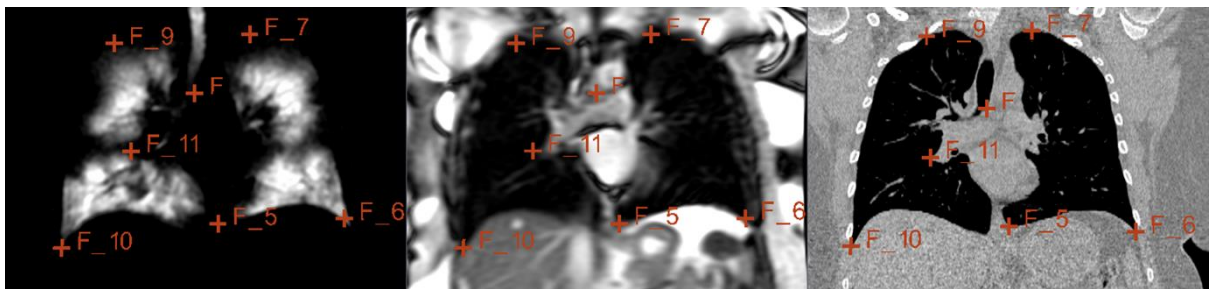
An example of corresponding landmarks identified on ^1H MRI (middle) and CT (right) images, alongside the ^3He MRI (left) that was acquired in the same breath hold as the ^1H MRI.
